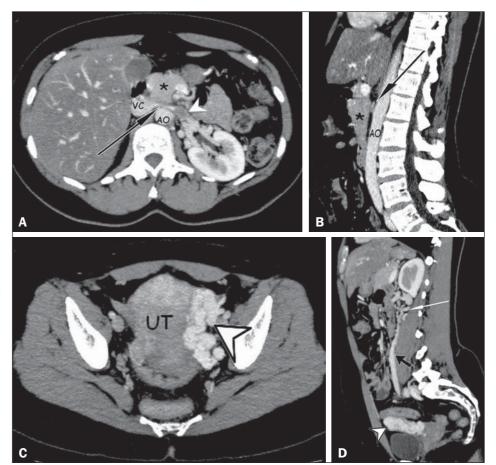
A,B: Contrast-enhanced arterial-phase CT of the abdomen, in the axial plane and in sagittal reconstruction, respectively, characterizing clots within the proximal portion of the LRV (white arrowhead), showing a reduction in its caliber at the aortomesenteric compression (black arrows), close to its junction with the inferior vena cava (VC), due to the extrinsic compression exerted by the uncinate process of the pancreas (asterisks) against the aorta (AO). Additional finding: diffuse hypointense signal in the hepatic parenchyma, suggesting fatty infiltration. C,D: Contrast-enhanced arterial-phase CT of the abdomen, in the axial plane and in sagittal reconstruction, respectively, showing dilation of the pelvic vessels (arrowheads) near the left lateral aspect of the uterus and the left gonadal vein (black arrow), with dilated collateral veins in the ipsilateral perirenal space (white arrow).
